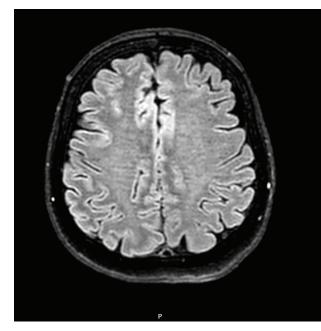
MRI flair sequence.
